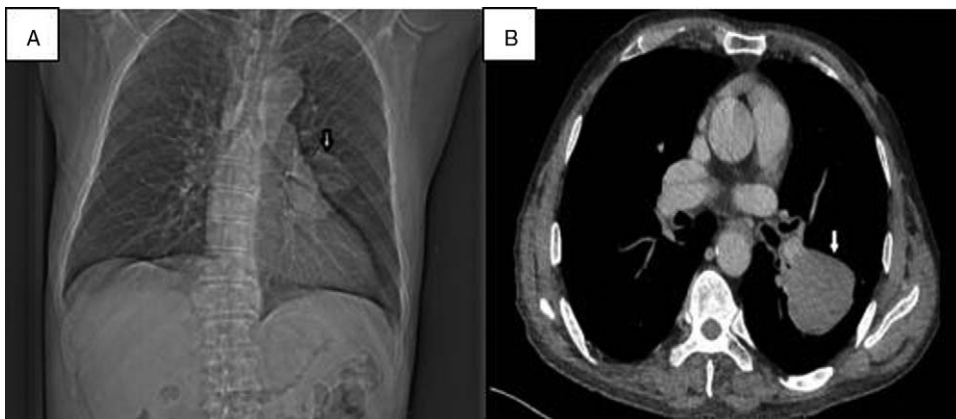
(A) Chest radiograph demonstrates a left lower lobe mass (arrow). (B) Chest computed tomography reveals a 6.4 cm mass (arrow) in the left lower lobe.
